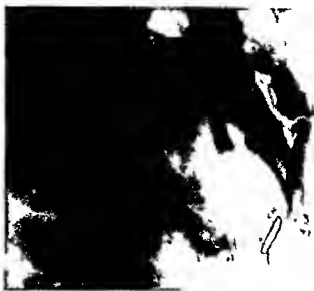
Roentgenogram showing bone graft from crest of ilium filling defect of mandible
